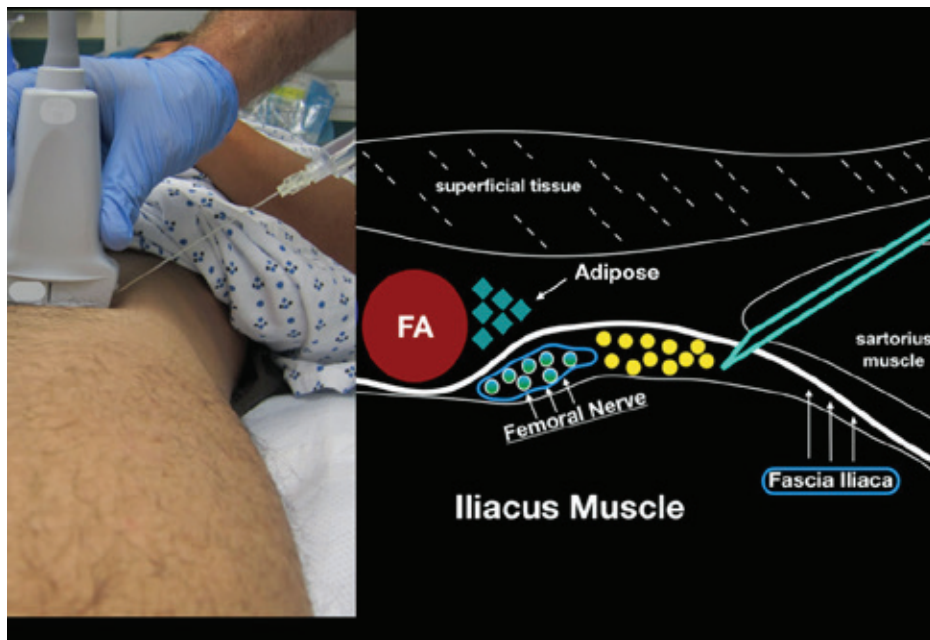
When performing an in-plane lateral to medial approach to the ultrasound-guided femoral nerve block, obtain clear sonoanatomy by proper probe positioning. Try to get your block needle just under the fascia iliaca (lateral to the femoral nerve) and inject anesthetic gently.
